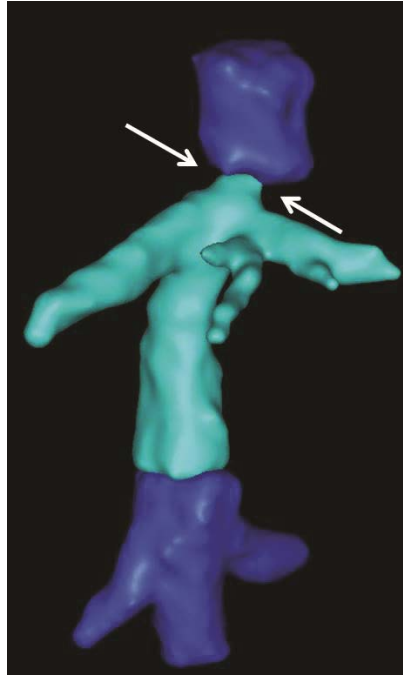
Computed tomography imaging (3D reconstruction) at early stages after liver transplantation when performing caval-caval reconstruction according to the classic technique, white arrows indicate the proximal anastomosis stenosis at the level of the diaphragm
